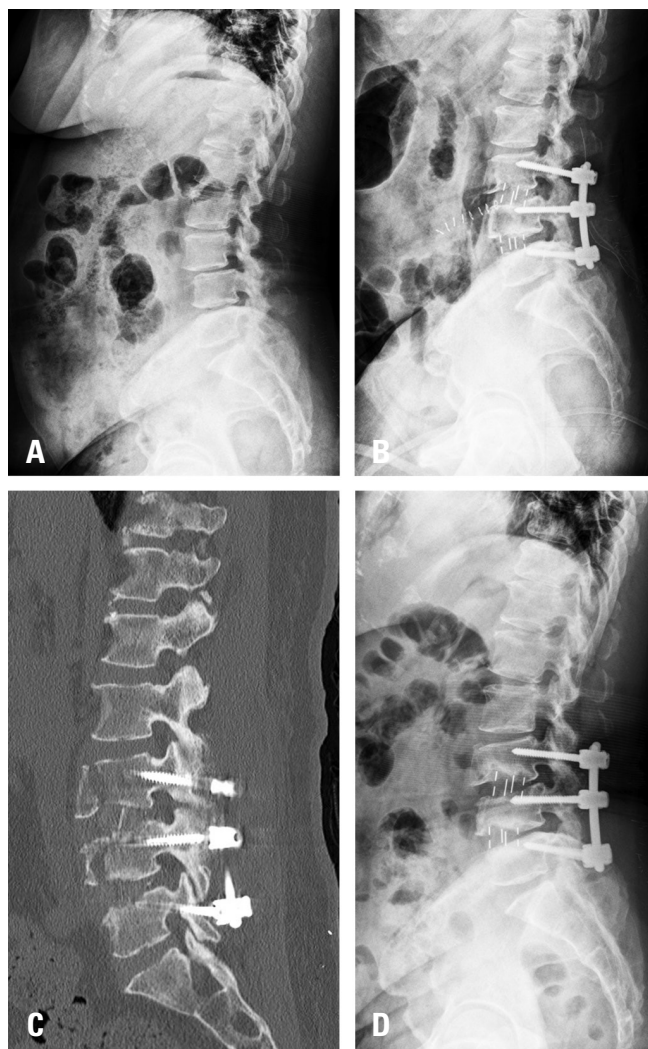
(A) Preoperative and (B) immediate postoperative lateral radiographs of a 60-year-old female patient. (C) Computed tomography scans showing a L3-4 vertebral coronal fracture at 1 week postoperatively. The fracture site showed union at 6 months postoperatively. (D) The fracture site showed union at 6 months postoperatively.
